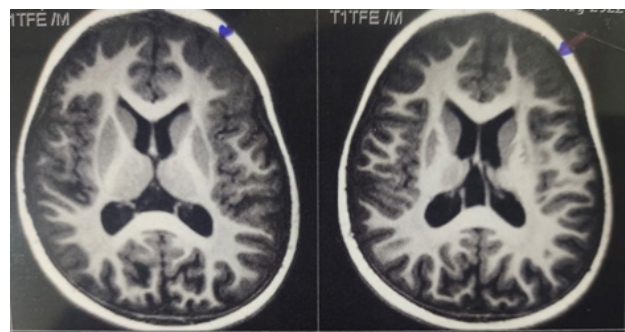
patient 2 MRI Brain suggestive of Enlargement of right hemisphere with herniation towards left
